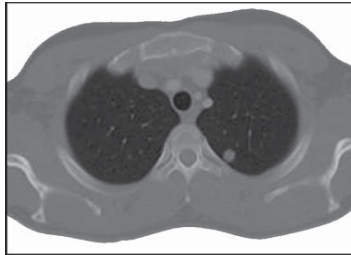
Chest CT: Axial Slice.
